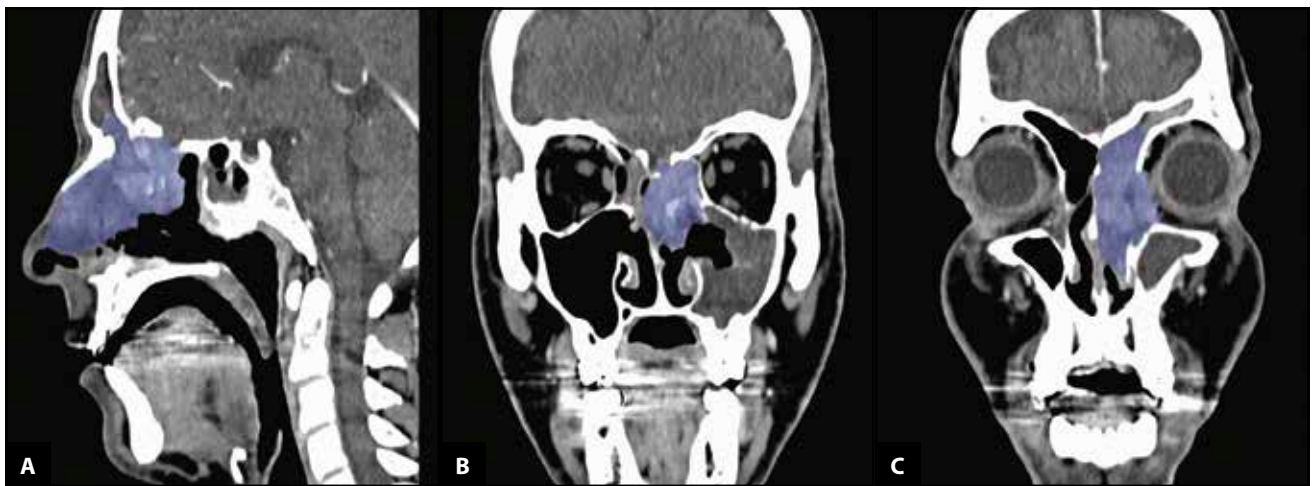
Contrast-enhanced computed tomography scan (CECT) sagittal (A) and coronal view (B, C) showing a heterogeneous moderate enhancement soft tissue mass occupying the left nasal fossa, with bone destruction of the left cribriform plate and intracranial extradural extension, destruction of the left medial wall of the maxillary sinus, lamina papyracea and extraconal intraorbital extension. Erosion of the posterosuperior part of the nasal septum.
